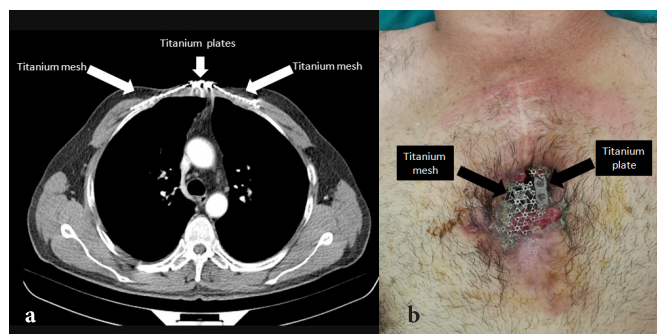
Postoperative chest CT of the patient (a), appearance of the wound one year after surgery (foreign body reaction and skin necrosis) (b).
